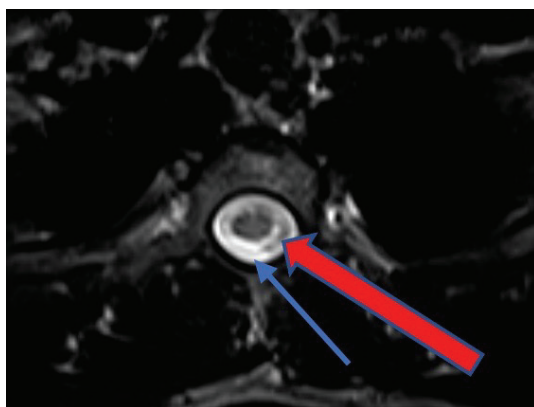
Axial T2 MRI, thoracic region, shows that extradural CSF accumulation (before lumbar puncture). Red arrow shows dura mater, blue arrow shows epidural space 5
